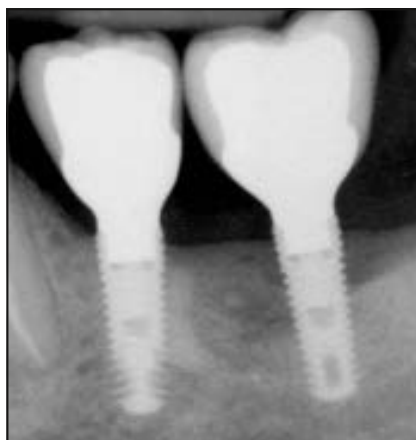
Periapical radiograph after implant insertion on the left side.
